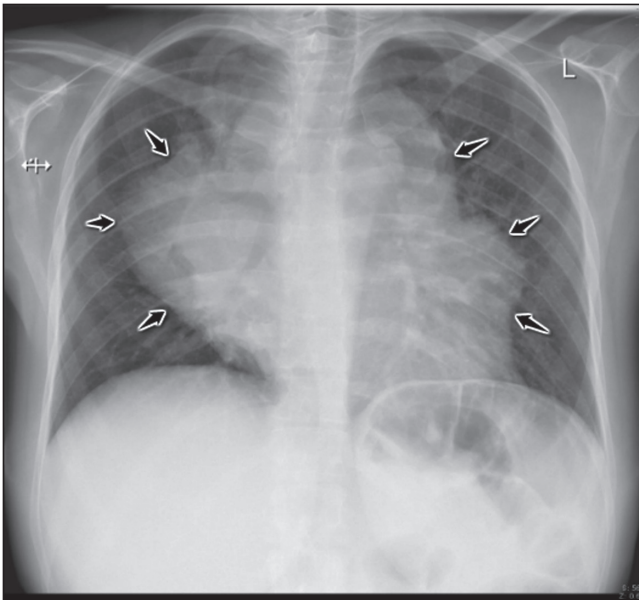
Chest radiographs showing a large ill-defined mediastinal mass inseparable from the cardiac silhouette (black arrows), posteroanterior view
